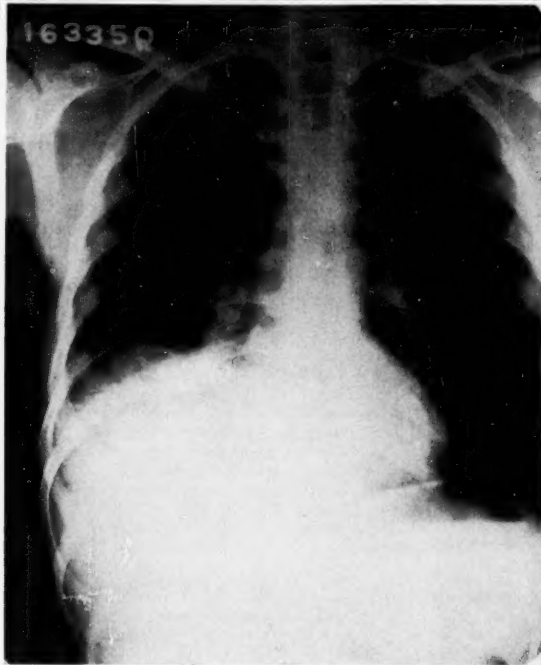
Chest x-ray of Case 3 (E. L. S.) on 63rd hospital day showing involvement of the base of the right lung within 24 hours after rupture of hepatic abscess and after 3 days of emetine therapy.
